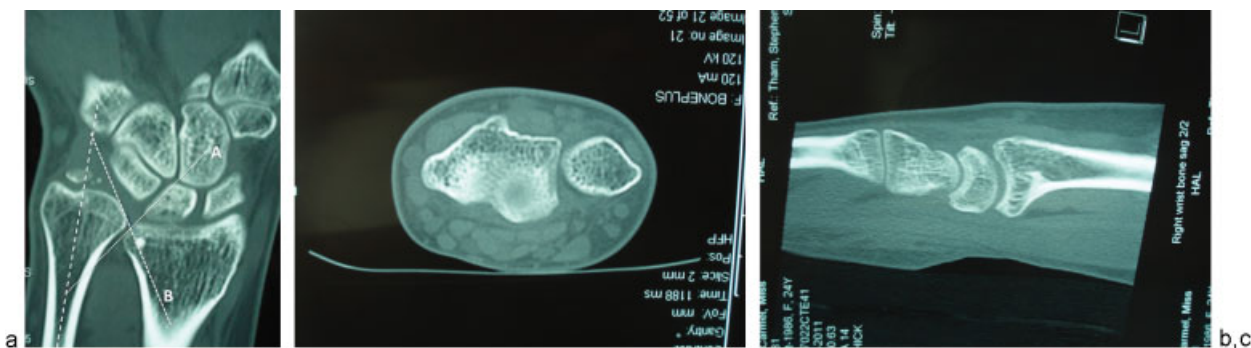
(a) Coronal CT scan showing reverse obliquity of the sigmoid notch and ulnar styloid non union. (b) Axial CT scan showing C-shaped sigmoid notch. (c) Sagittal image showing radial tilt of 0 degrees.
